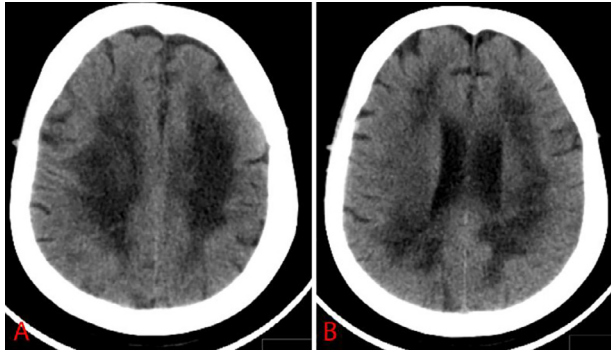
Follow-up CT scan of brain (second patient). Four weeks after prior MRI. (A and B) axial CT brain: demonstrate persistent diffuse white matter hypoattenuation.
